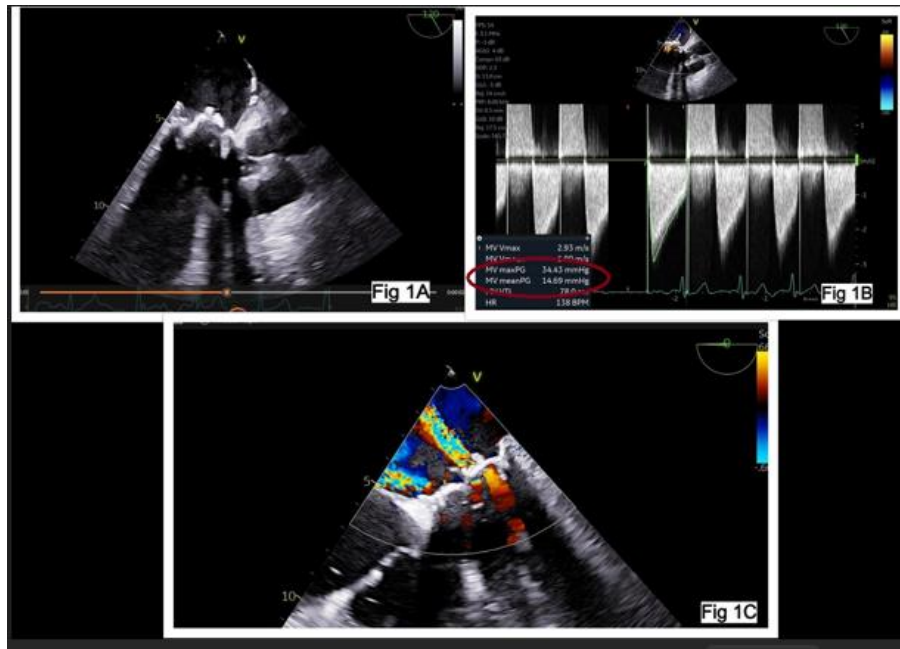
Transesophageal echocardiography showing degenerated bioprosthetic valve (Fig 1A) with severe mitral stenosis (Fig 1B) and severe mitral regurgitation (Fig 1C)
